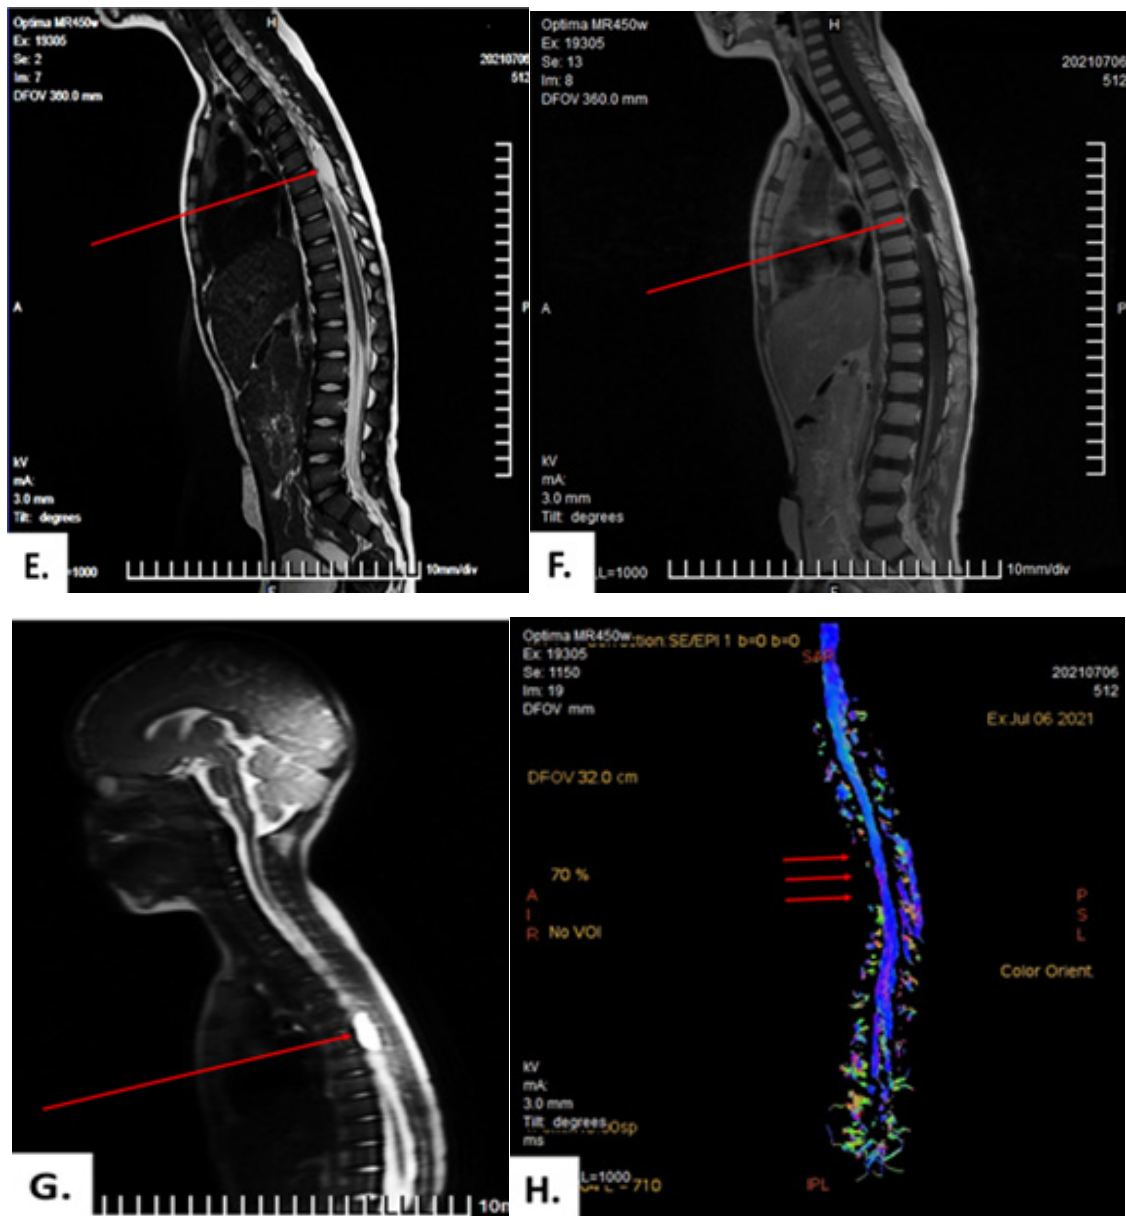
MRI signs of a cystic mass located extradural extramedullary in the spinal canal on the right at the level of the bodies of Th6-Th8 vertebrae, compressing the spinal cord. T2-contrast magnetic resonance imaging showing a well-defined hyperintense mass located extradural, extramedullary in the spinal canal on the right at the level of the Th6-Th8 vertebral bodies. MRI scans: T1 axial (A), coronal (C), T2 axial (B), coronal (G), sagittal (E), primary scan topogram (G), contrast sagittal (F), 3D tractographic map (H).
